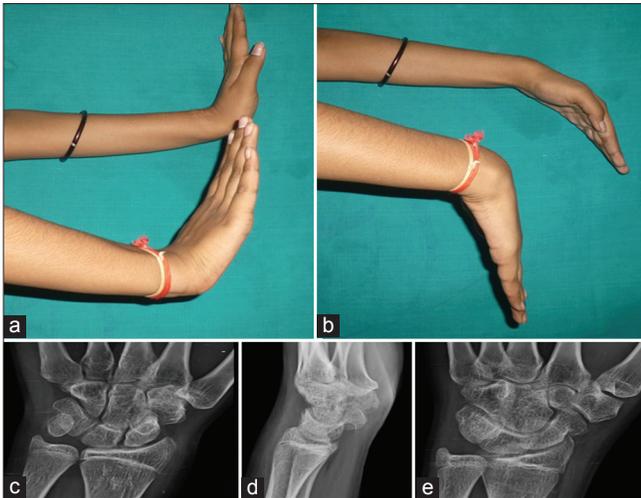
(a, b) Clinical photograph showing range of motion at the wrist at 1-year followup. (c, d, e) Radiograph of the wrist at 1 year showed no recurrence and no significant progression of arthritis
